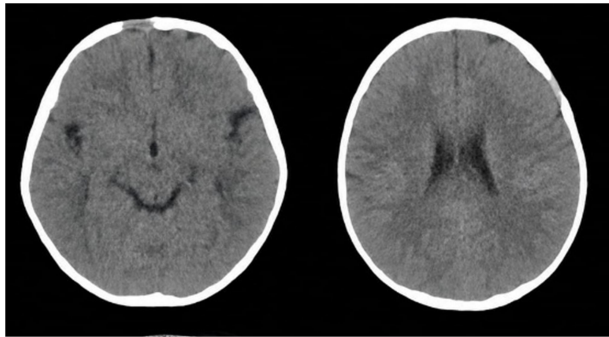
The following non-contrast axial CT images reveal a well-defined, beveled-edge lytic lesion in the frontal region measuring 2.1 x 1.3 cm; another lesion with similar characteristics is also observed in the left frontoparietal region adjacent to the coronal suture, measuring 2.8 x 1.5 cm. These findings represent lytic lesions consistent with Langerhans cell histiocytosis.
